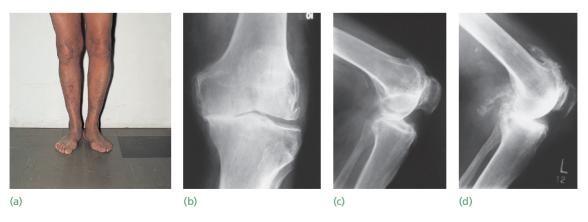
Osteoarthritis (a,b) Varus deformity of the left knee suggesting loss of cartilage thickness in the medial compartment. X-ray shows diminished joint space and peripheral osteophytes on the medial side of the knee. (c) Sometimes it is the patellofemoral joint that is mainly affected. (d) Patellofemoral osteoarthritis with long trailing osteophytes is typical of calcium pyrophosphate arthropathy.
